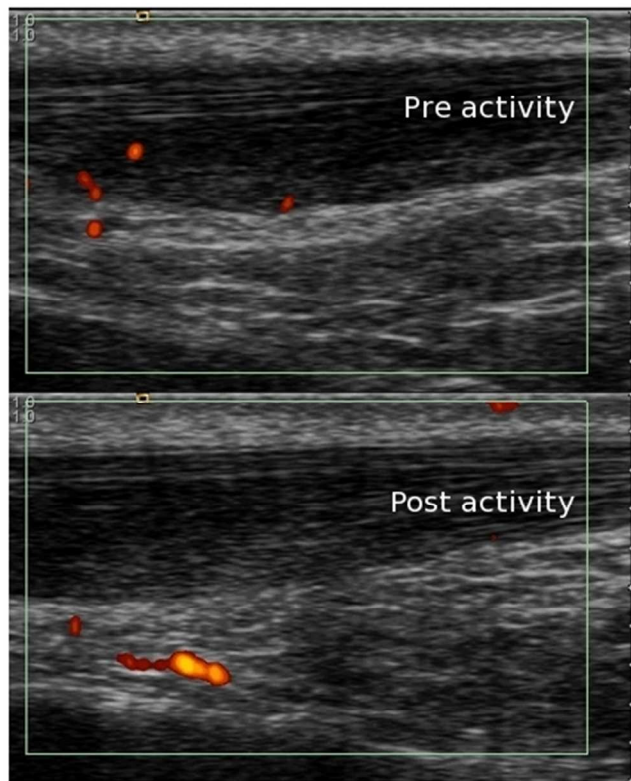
Doppler signal pre and post activity for one participant (Doppler signal is seen to resolve within the tendon and increase outside of the tendon)
